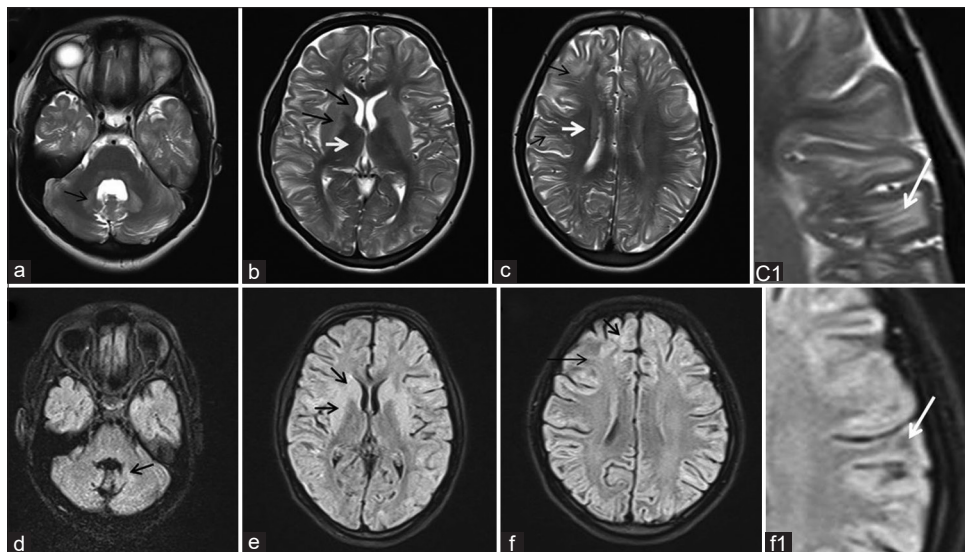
Axial T2-weighted/fluid-attenuated inversion recovery images showing bilaterally symmetrical T2-weighted/fluid-attenuated inversion recovery hyperintense lesions in the dentate nuclei (black arrow in a and d), caudate nuclei and bilateral lentiform nuclei (black arrows in b and e), subcortical white matter (black arrows in c and f, with white arrow in insert C1 and f1), sparing of bilateral thalami and periventricular white matter (white arrows in b and c)
